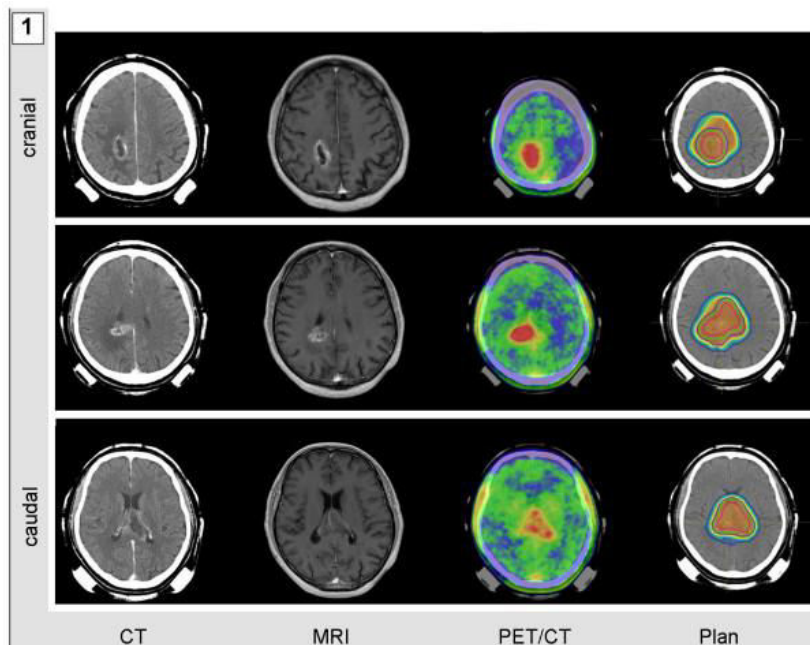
Extensive glioblastoma multiforme in a 62-year-old man. Contrast-agent enhanced CT and MRI scan were fused with a FET-PET/CT examination and used to decide the right radiotherapy plan²¹.
